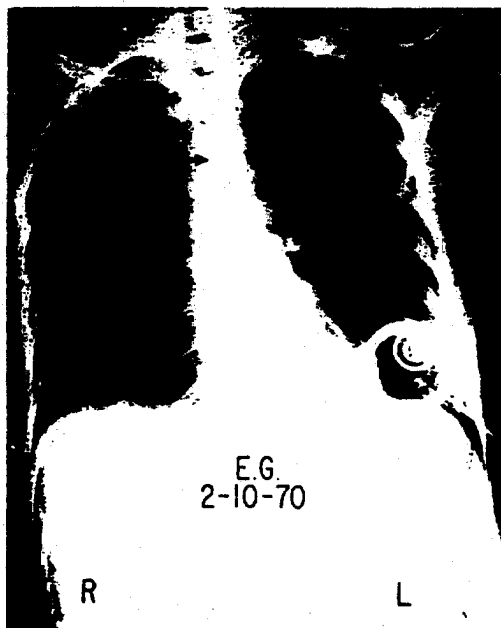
Roentgenogram of patient with bilateral thoracic DCS. Subcutaneous rf receiver and external antenna seen on left. Arrow indicates contacts on DCS implant.
